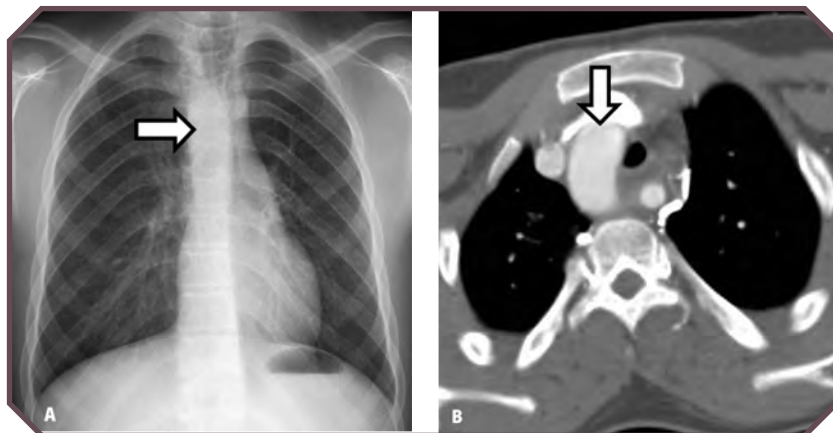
Right aortic arch in a 14-year-old female patient. A. Posteroanterior chest radiograph shows a soft-tissue density (arrow) along the right side of the trachea. B. Axial contrast-enhanced computed tomographic image confirms a right aortic arch (arrow).
